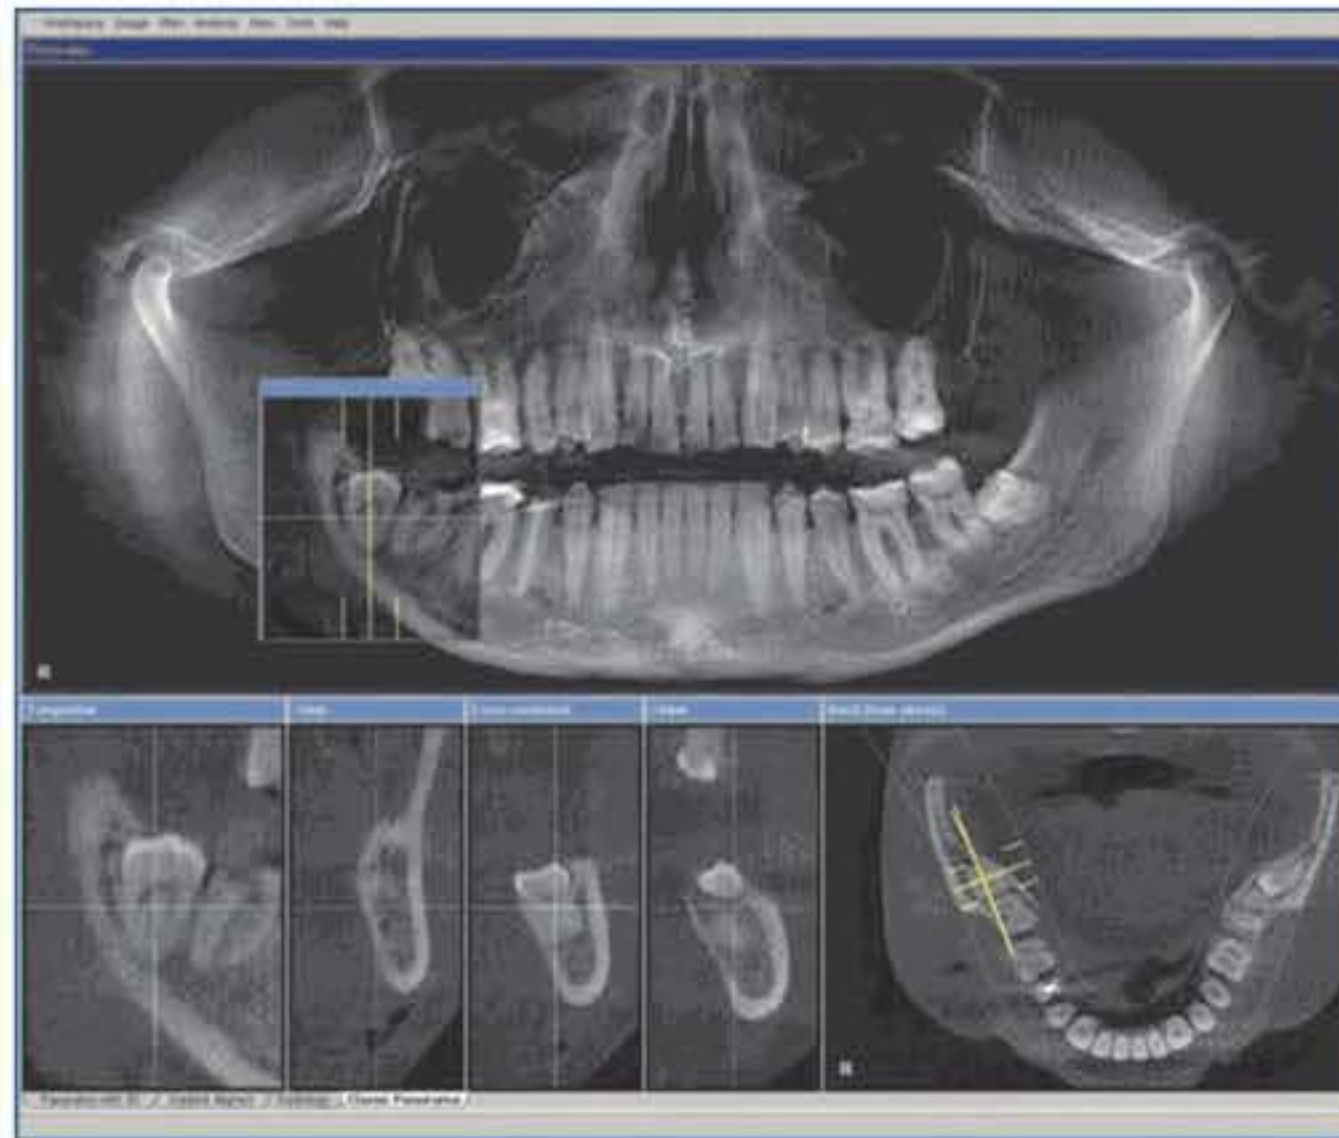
A 55-year-old male with impacted 38 and 48. (a) In the panoramic view, the transverse displacement of 38 looks as it does in a classical orthopantomograph image. The pericoronal lucency can only be discerned mesially at tooth 48. The transition between root and bone is indiscernible, particularly at the level of the nerve canal running vestibularly. (b) In horizontally distally displaced tooth 38, the lingual root path and the vestibular course of the inferior alveolar nerve relative to the root can be seen. The round projection seen in the panoramic representation is a physiological tooth shape in the slice image.
